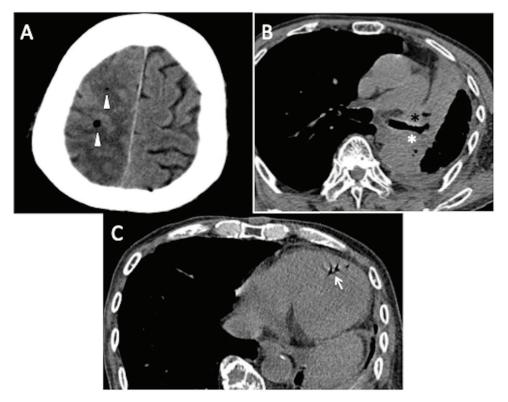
Brain CT scan on hospital day 8 showing air densities (arrowhead) around the infarct areas (A). Chest CT scan showing the left pulmonary hilar mass invading the left pulmonary vein (black asterisk), left atrium (white asterisk), and main bronchus (B). Chest CT scan showing air densities (arrow) in the left heart ventricle (C).
